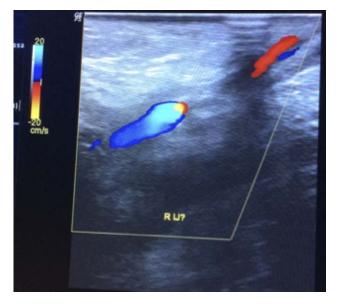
Doppler ultrasonic evaluation of right internal jugular vein to right external jugular vein anastamoses, demonstrating venous flow and effective patency.
